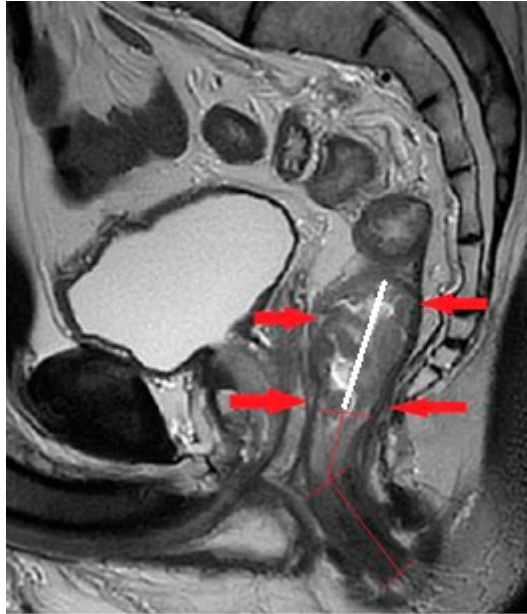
Measurement of tumor height using magnetic resonance imaging*
